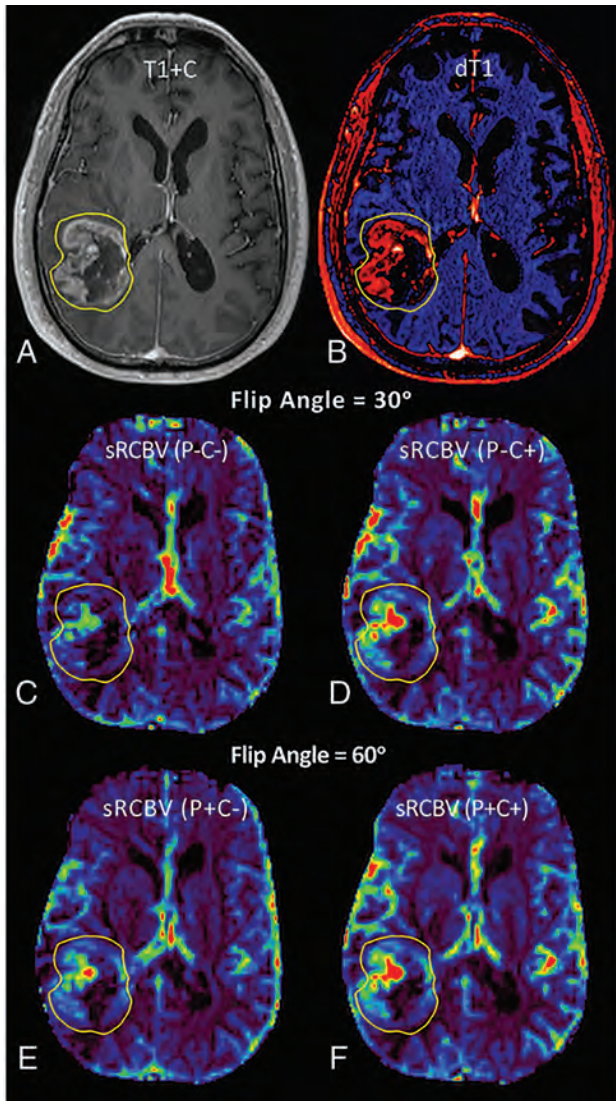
Images and sRCBV parameter maps from a patient with glioblastoma. Shown are the post-contrast T1-weighted (T1+C) (A) and quantitative dT1 (B) images with the corresponding sRCBV maps obtained from the first DSC-MR imaging contrast dose (C and D) without preload (P-) and without leakage correction (C-) and without preload (P-) plus leakage correction (C+). The sRCBVs obtained during the second contrast dose (E and F) and thus after the preload are shown without (P+C-) and with (P+C+) leakage correction.
